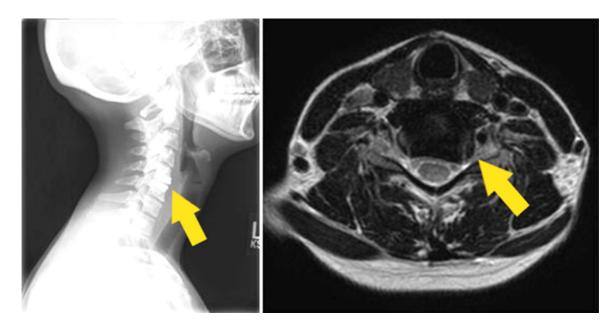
Prechiropractic care radiograph and MRI. Disk herniation of the C6-7 disk with protrusion to the left side can be seen (right), as well as the previous cervical total disk replacement of the C5-6 disk (left).
